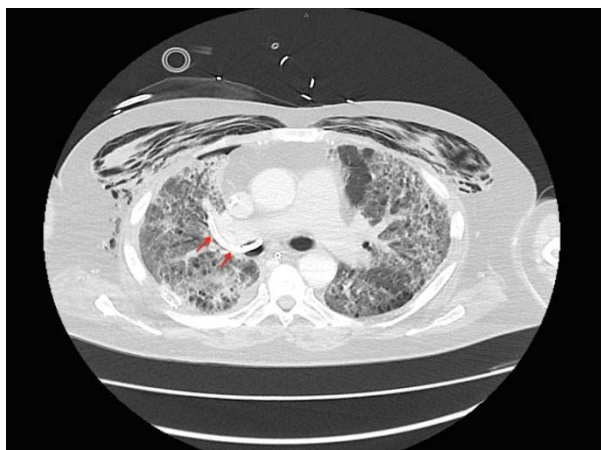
Chest CT (transverse view) showing pigtail in the right mainstem bronchus - with arrows.
